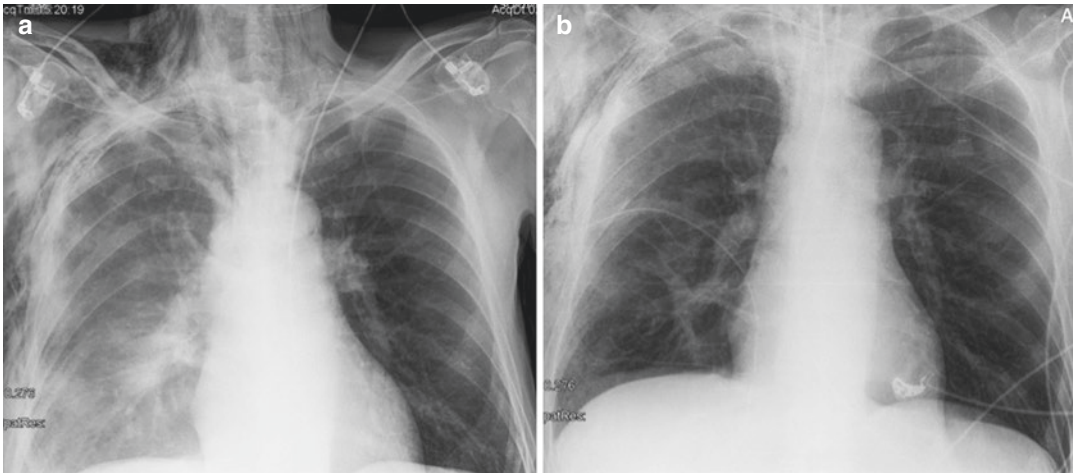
Chest X-ray (CXR) in (a) shows an opacification of the right hemithorax caused by a massive hemothorax; subcutaneous emphysema is associated. CXR control after drainage positioning (b)
